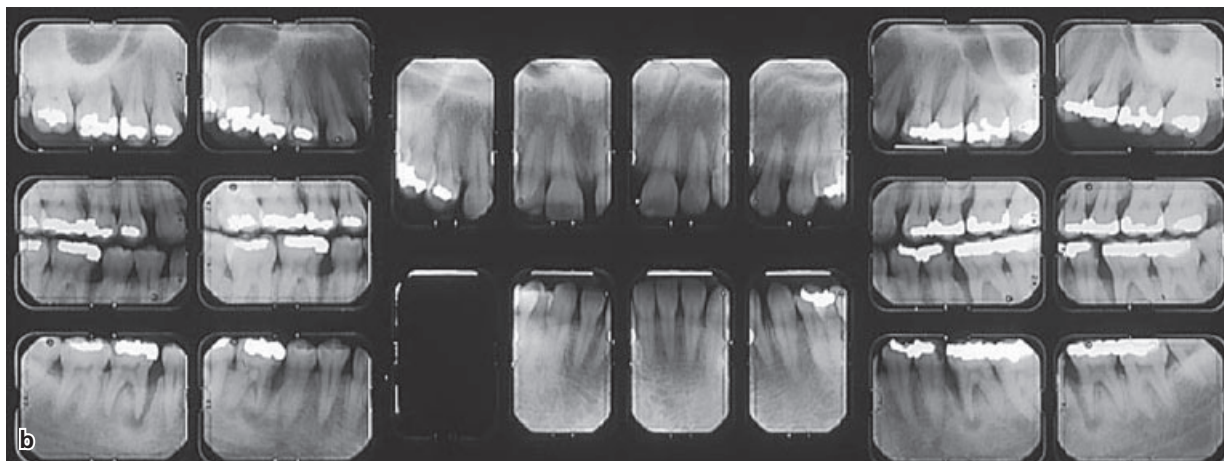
(a,b) Clinical and radiographic presentation of a 22-year-old African-American female. Clinical attachment loss and alveolar bone loss are localized on the mesial aspect of the first molars, where deep, vertical defects are apparent. (c–e) Detailed views of the defect on the mesial aspect of 26. No other tooth appears to be affected. Microbiology (DNA probe analysis of *A. actinomycetemcomitans*, *P. gingivalis* and *P. intermedia*) confirmed the presence of high levels (>10⁴ bacteria/sample) of *A. actinomycetemcomitans* in all four deep lesions. *Pr. intermedia* was also detectable in three of four sites, while *P. gingivalis* was undetectable. The patient did not display abnormal leukocyte functions; furthermore, she had a non-contributory medical history, and did not smoke. She had a younger brother (15 years old) and an older sister (27 years old); on clinical examination, the periodontium of both of them appeared to be within normal limits. The following diagnosis was made: "LAP in a 22-year-old systemically healthy African-American female; associated with *A. actinomycetemcomitans* infection without clinically detectable levels of *P. gingivalis*; absence of demonstrable leukocyte defects; no known contributory factors; no cigarette smoking; no siblings displaying clinically detectable AgP".
